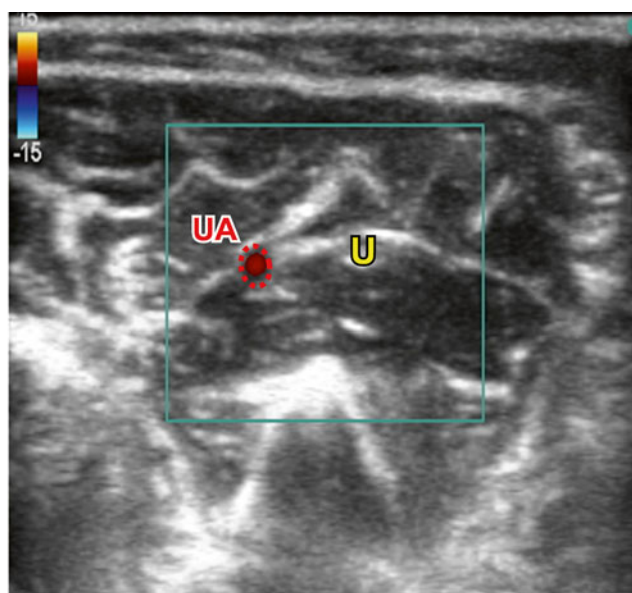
Ultrasound image of the ulnar nerve in the forearm. UA ulnar artery, U ulnar nerve
